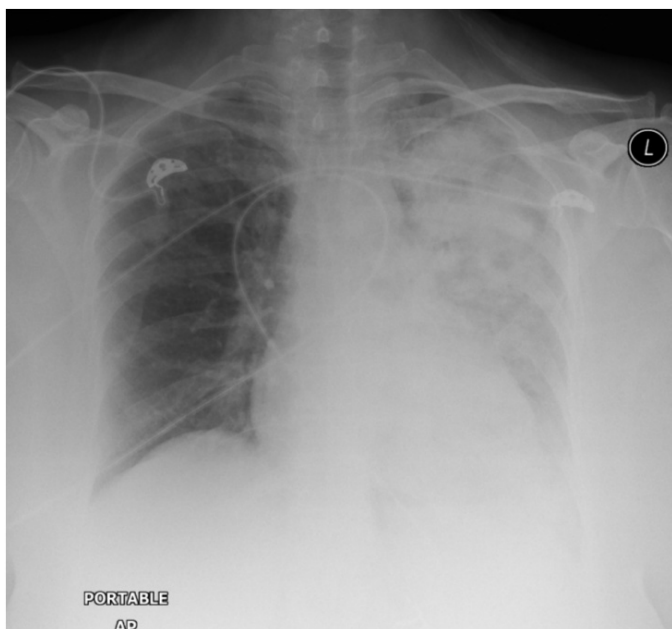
Chest X-ray with diffuse patchy airspace opacities more pronounced in the left lung.
